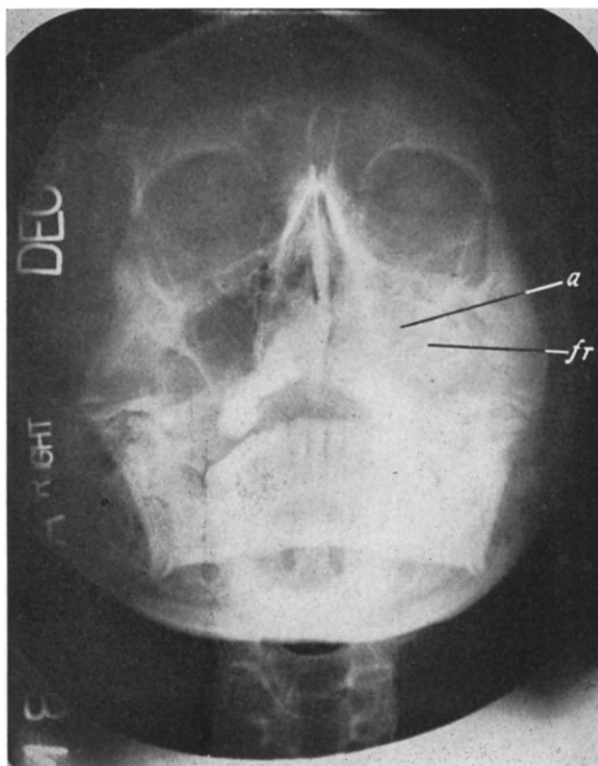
A. X-RAY PICTURE OF FRACTURE OF LEFT MALAR BONE
